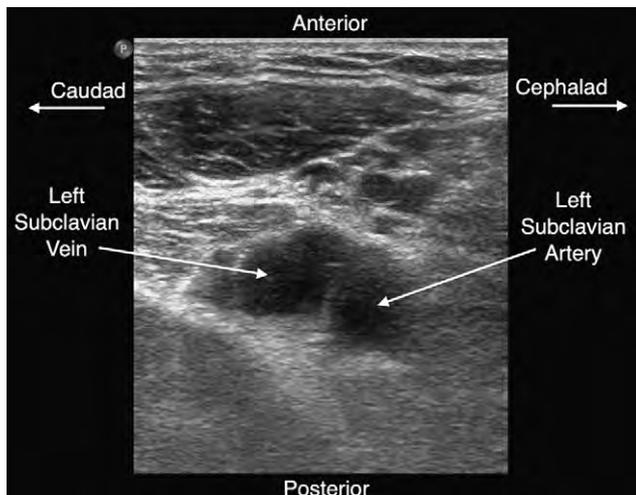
Two-dimensional ultrasound image of the left SC vein and left SC artery obtained from the left side of the patient during ultrasound-guided cannulation of the left SC vein.
